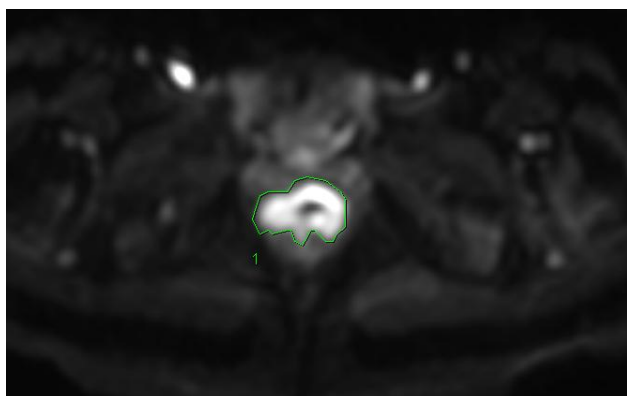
DWI showing restricted diffusion within the lesion.
